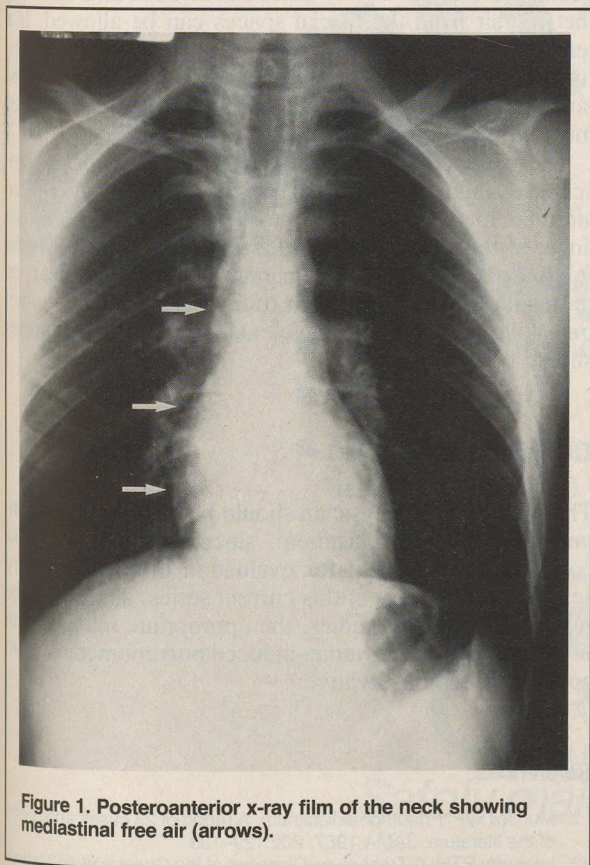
Posteroanterior x-ray film of the neck showing mediastinal free air (arrows).
